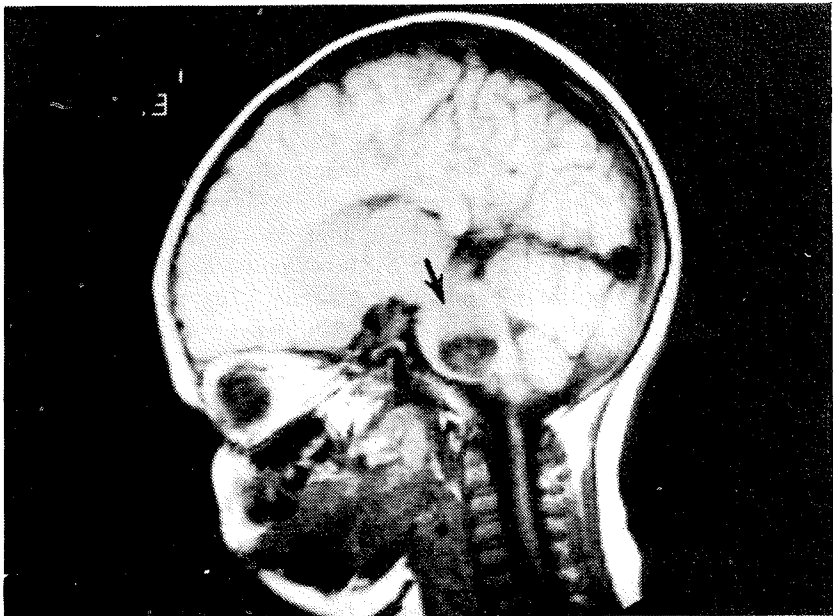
Partially Cystic Pontine Glioma. Sagittal MR image shows expanded pons with cystic portion (arrow).
